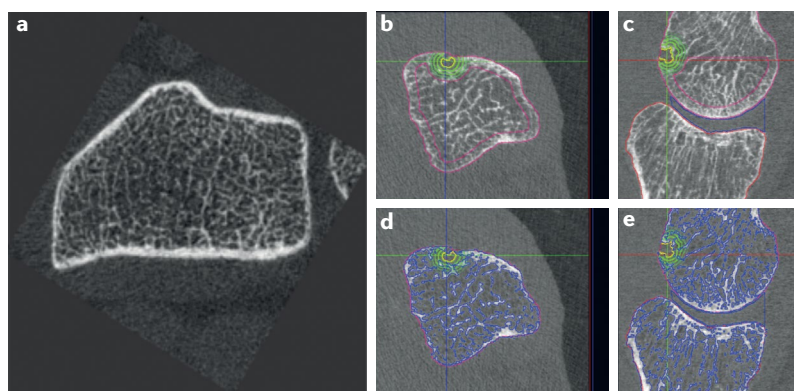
HR-pQCT in the clinic. Analysis of the distal radius (a) and metacarpophalangeal (MCP) joints (b–e) showing bone erosions in a patient with rheumatoid arthritis using high-resolution peripheral quantitative CT (HR-pQCT). a | Selected axial slice demonstrating the excellent spatial resolution achieved with HR-pQCT, which is adequate for structural analysis of the trabecular network. b | Axial and c | coronal reconstructions of the second MCP joint, selected from a standard scan that included second to fourth MCP joints. Periosteal bone contours (pink), the trabecular volume of interest (VOI) of the metacarpal head (red) and joint space VOI (blue) are visible. The contour of the erosion is highlighted in yellow. Contours of four concentric VOIs around the erosion are used to measure bone mineral density of the sclerotic rim of the erosion. d | and e | Reconstruction of the same scans as shown in c and d, showing the contours of individual trabeculae (blue).
